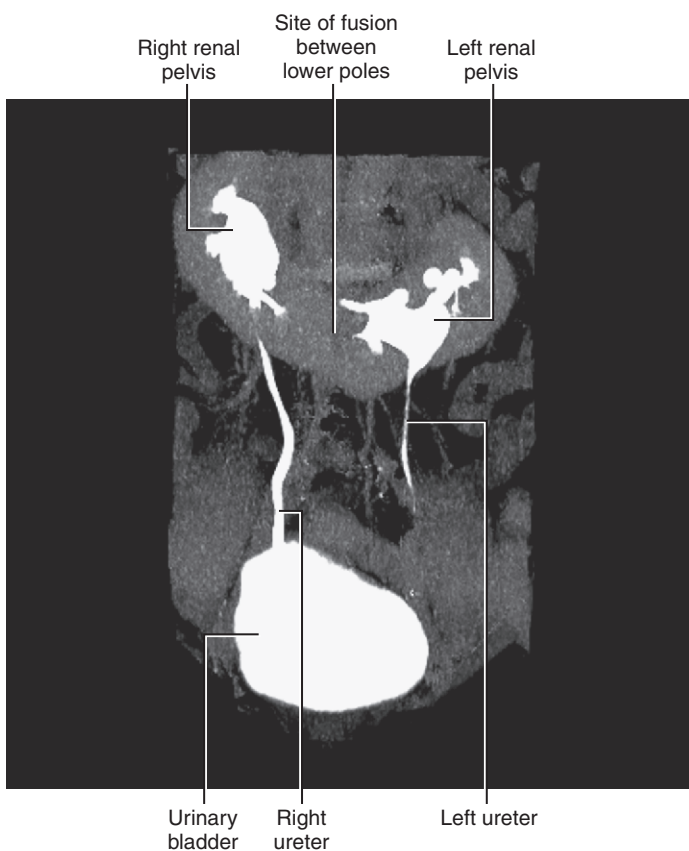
Horseshoe kidney. Three-dimensional volume reconstruction image, CT urogram, showing fusion of the lower poles of the right and left kidneys. Both kidneys appear to have dilated renal pelvises and some degree of caliectasis, suggesting impaired drainage. (Image courtesy of Raj Paspulati, MD.)
